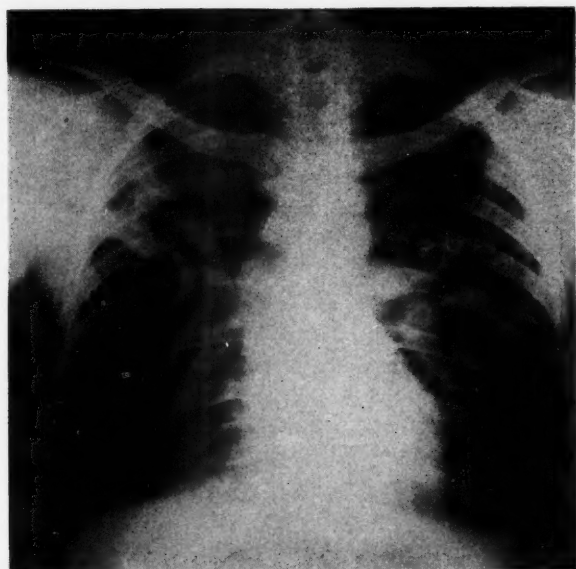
Chest roentgenogram, January 11, 1947, showing moderately dense bilateral pulmonary infiltration.
